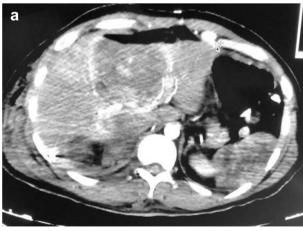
(a and b) CT image showing liver laceration with contrast extravasation denoting active bleeding and perihepatic fluid collection. CT, computed tomography.
